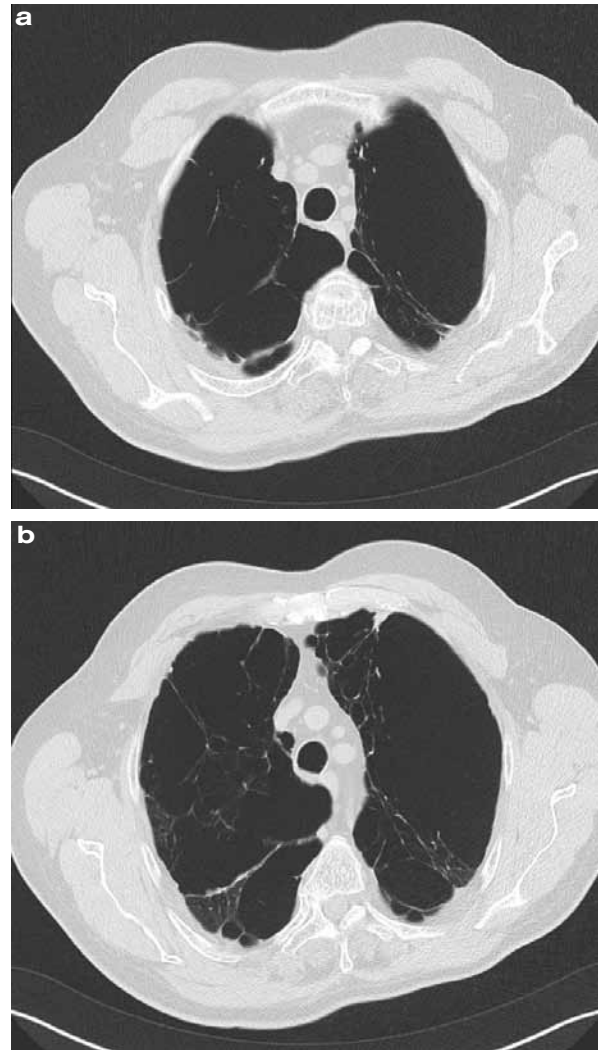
a CT- scan revealed severe heterogeneous centrilobular lung emphysema with bilateral involvement of the upper lobes.
